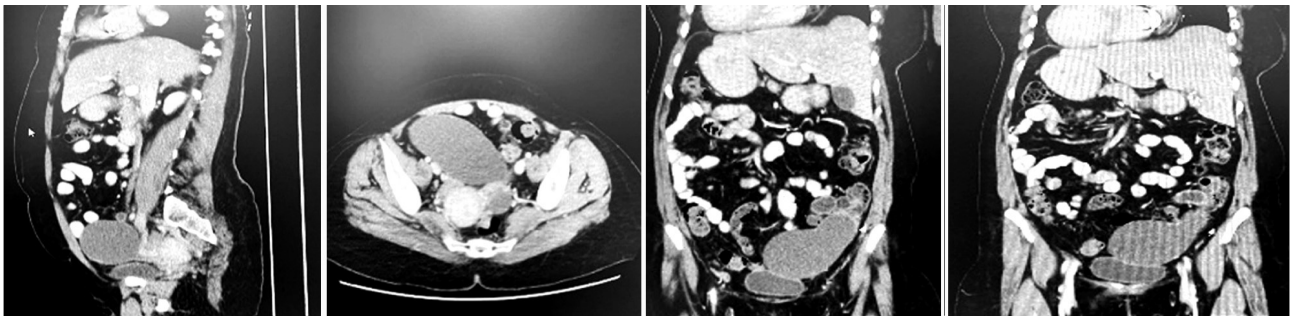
Magnetic resonance imaging showed an impression of a mesenteric cyst
